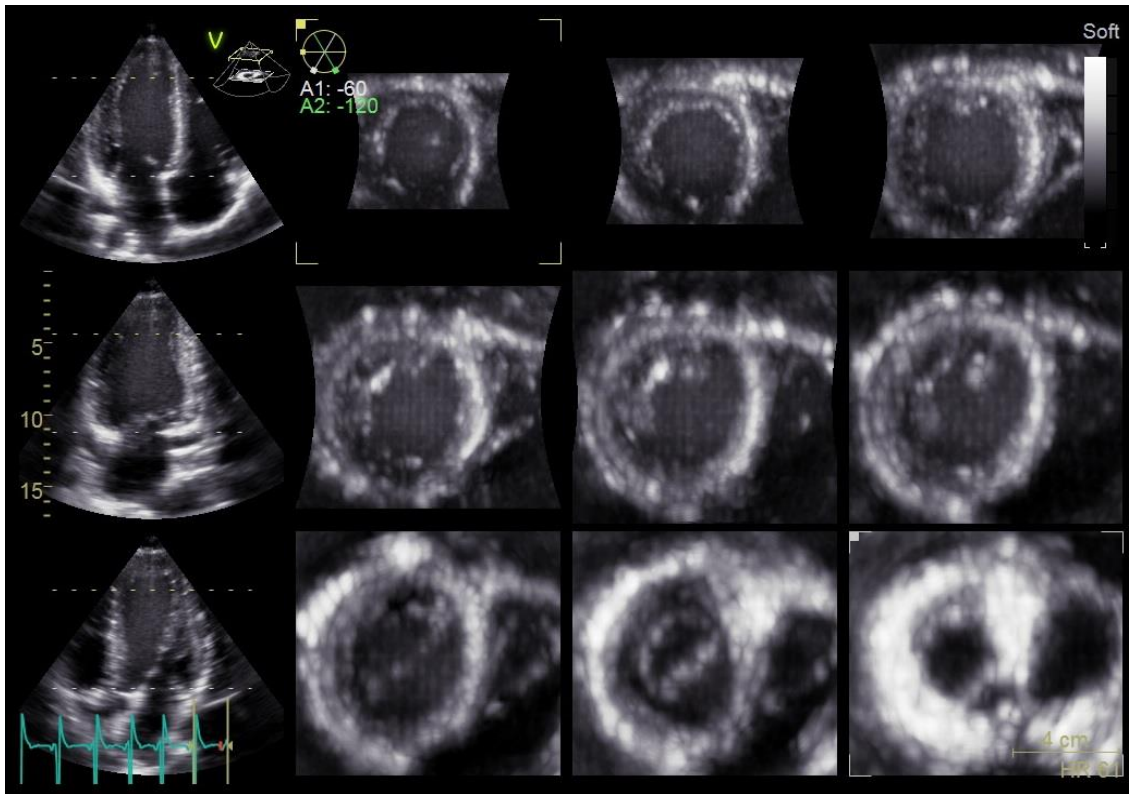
3D echocardiography of the left ventricle and the left atrium. The software shows long-axis and short-axis views of the chambers simultaneously. Various vendor-dependent or even independent software solutions are available to extract volumetric and deformation data from raw 3D images.
